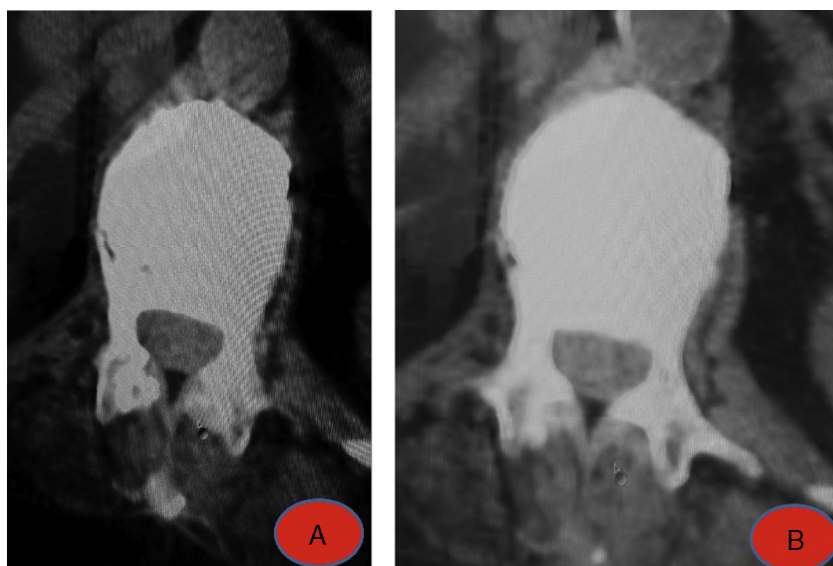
(A and B) Postoperative CT.
